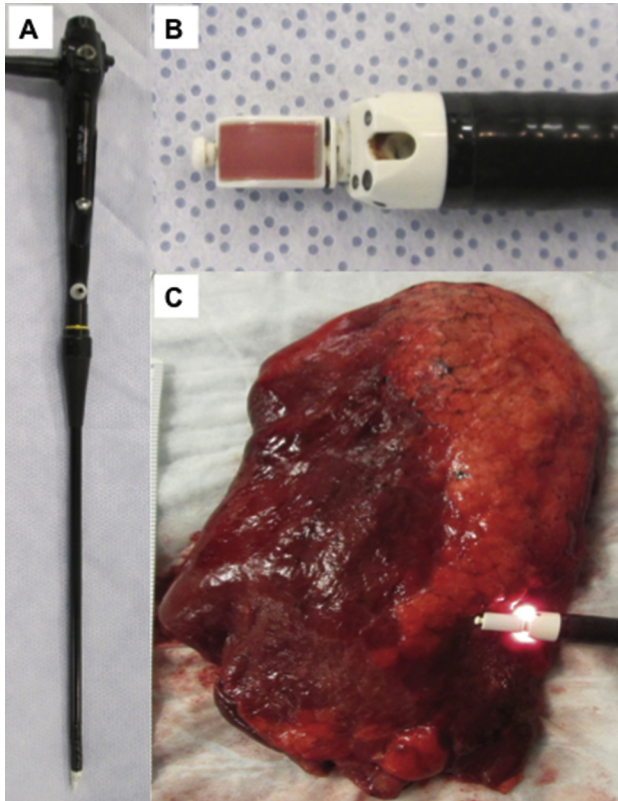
(A) Body of the prototype ultrasound thoracoscope (XLTF-UC180; Olympus, Tokyo, Japan). (B) Tip of the ultrasound thoracoscope. The outer diameter is 10 mm for use in minimally invasive surgery. A charge-coupled device camera and two light sources are situated on the tip of the thoracoscope. The accessory channel diameter is 2.2 mm. (C) The ultrasound thoracoscope is placed on the deflated human lung surface to localize lung tumors.
